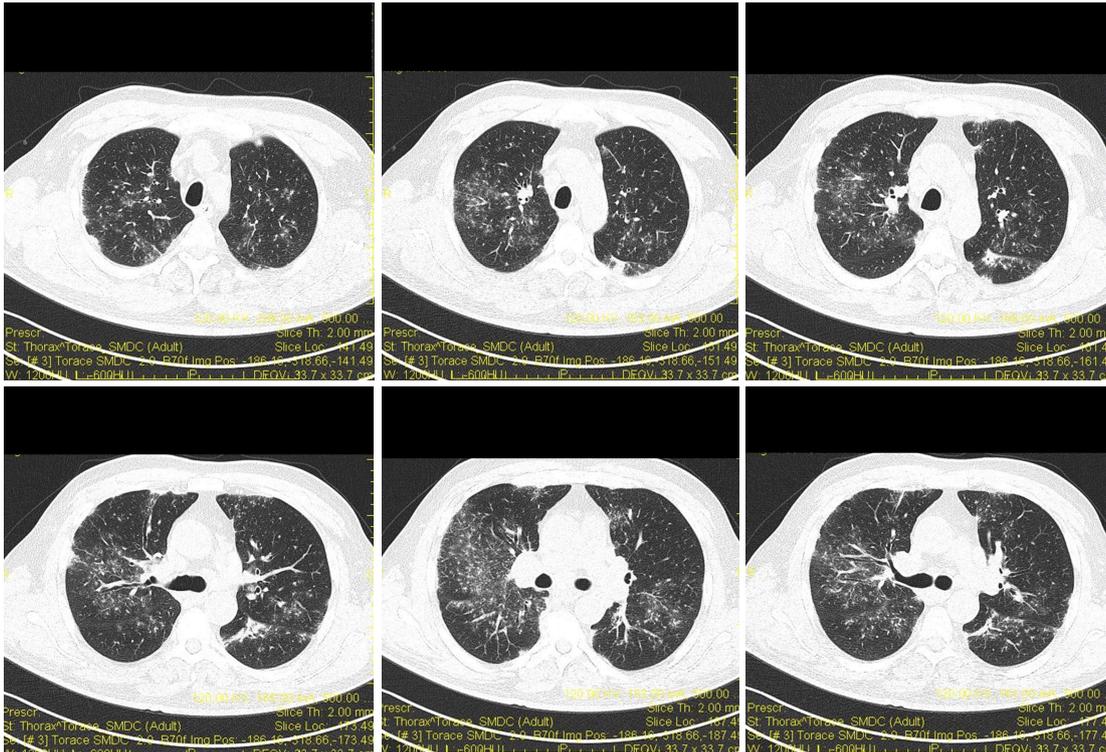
Pulmonary computed tomography.
